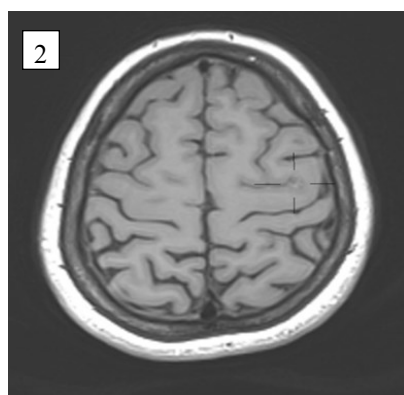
24 months post treatment T1 MRI image showing complete obliteration of AVM nidus.
